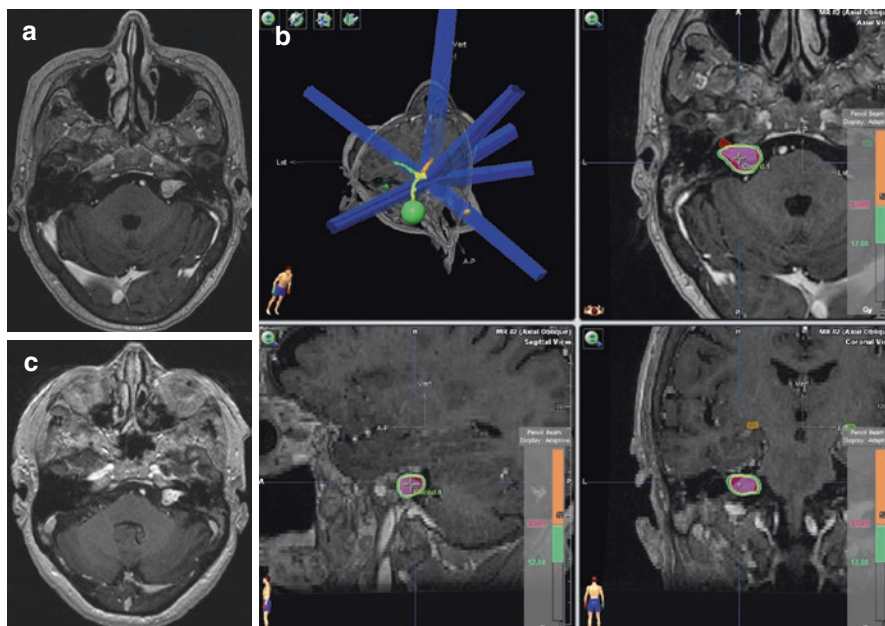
Left vestibular Schwannoma. (a) MRI before SRS. (b) Treatment plan SRS, Dose prescription 13 Gy periphery. (c) MRI 1 year follow up
